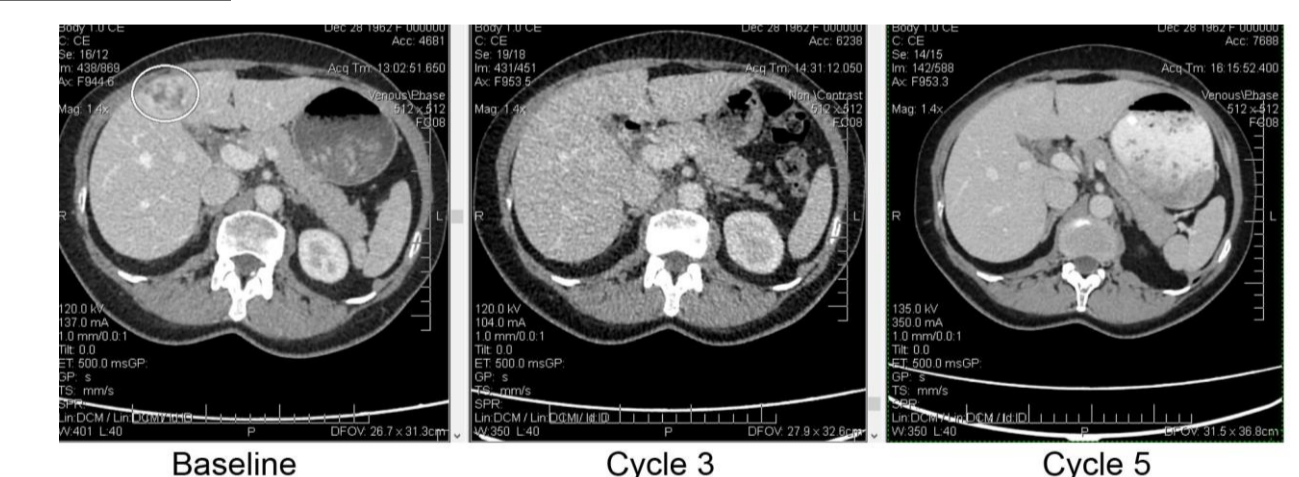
CT Scan images of a patient who showed PR
